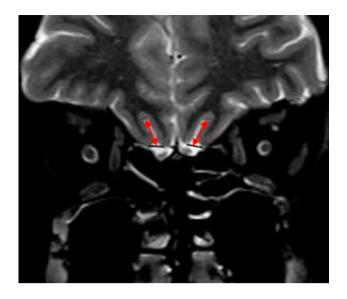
Olfactory sulcus depth measurement with magnetic resonance imaging. Coronal T2-weighted image shows an example measuring of olfactory sulcus depth
